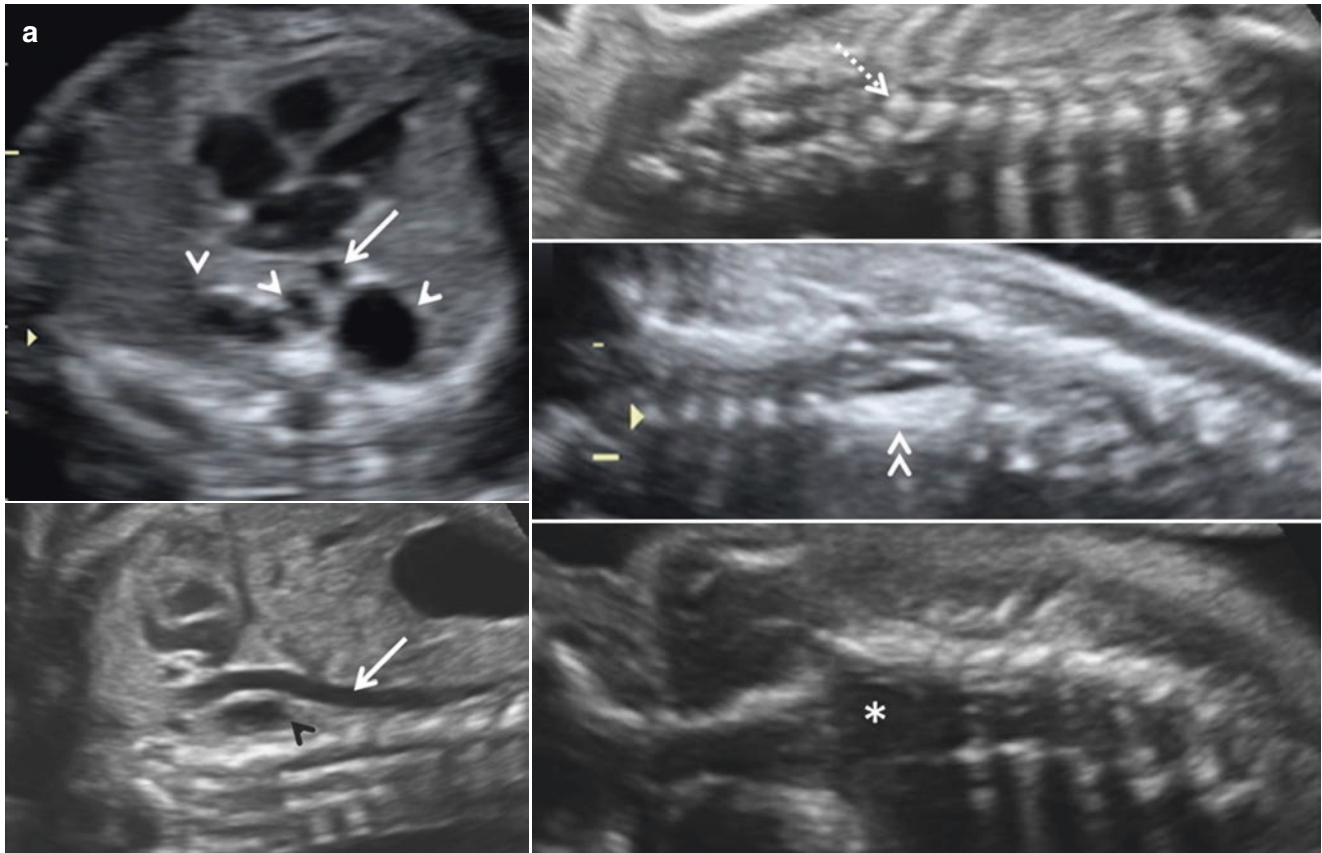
(a) 24 weeks (TAS and MRI) *neurenteric cyst* – axial and sagittal sections of thorax, anterior and posterior coronal sections of thoracic spine – retrocardiac, retroaortic, prevertebral tubular folded cystic lesion (arrowheads), descending aorta (solid arrow), hemivertebra (dotted arrow), block vertebra (double arrowhead) and widening of the vertebral canal (*). The spinal findings are at the same level as the posterior mediastinal cystic lesion. (b) 24 weeks (TAS and MRI) *neurenteric cyst* – coronal and sagittal sections of thoracic spine, coronal
